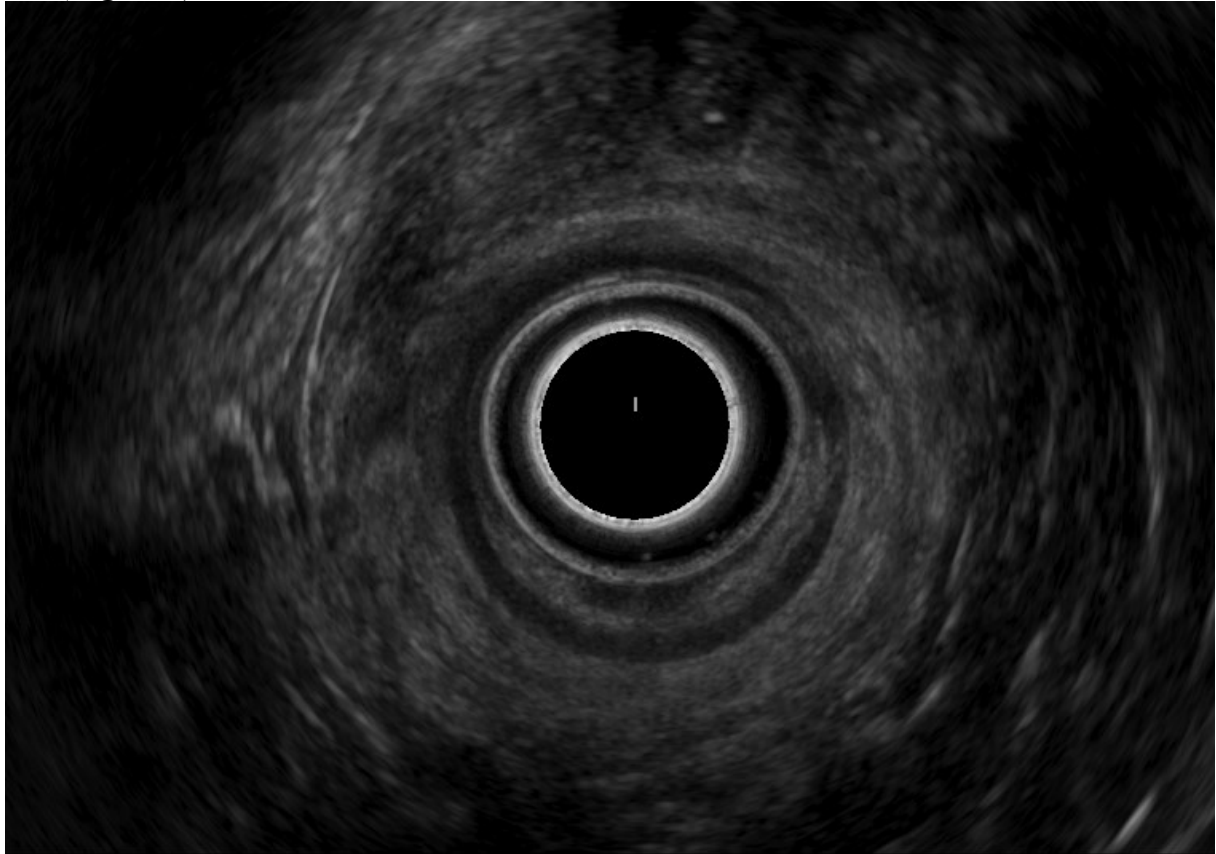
Normal view of the rectal wall with a radial probe in Rectosigmoid Endoscopic Ultrasonography.
